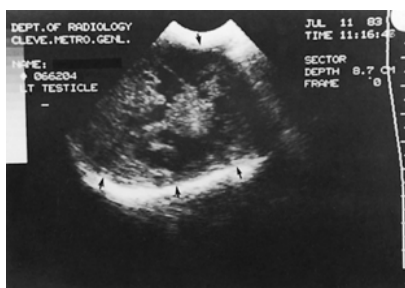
32. Scrotal ultrasound demonstrating large inhomogeneous testicular mass (arrows). Pathologic examination revealed embryonal cell carcinoma.
